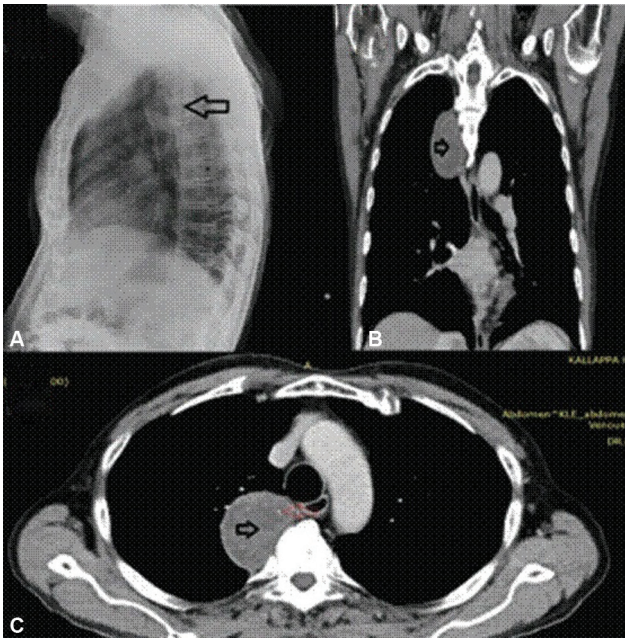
Neurogenic tumor. Lateral radiograph (A) demonstrating a lesion in the posterior mediastinum (arrow). Coronal reformatted image (B) demonstrating a homogeneously enhancing oval-shaped lesion (arrow) in the right paravertebral region with enhancing septations, and axial contrast-enhanced computed tomographic image (C) demonstrating a homogeneously enhancing oval-shaped lesion (black arrow) with foci calcification (red arrow).
